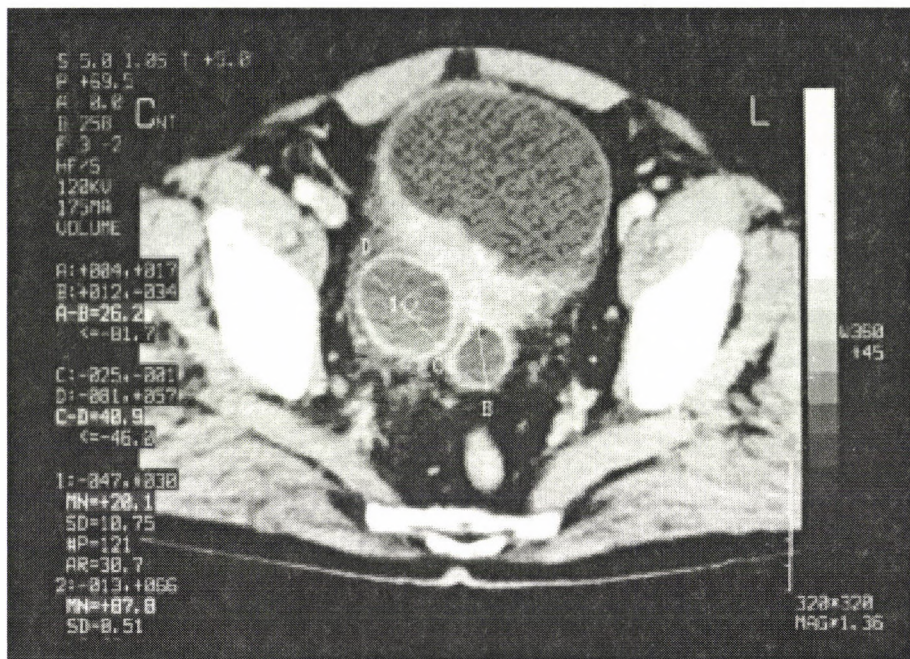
Contrast CT image; the uneven thickening of the bladder wall, perivascular infiltration and two diverticuli are visible
